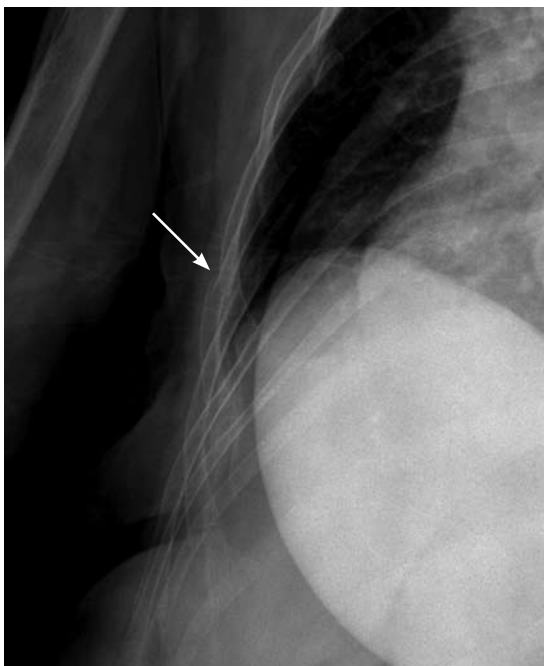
Oblique radiographic view shows an acute rib fracture in a patient with multiple myeloma.
